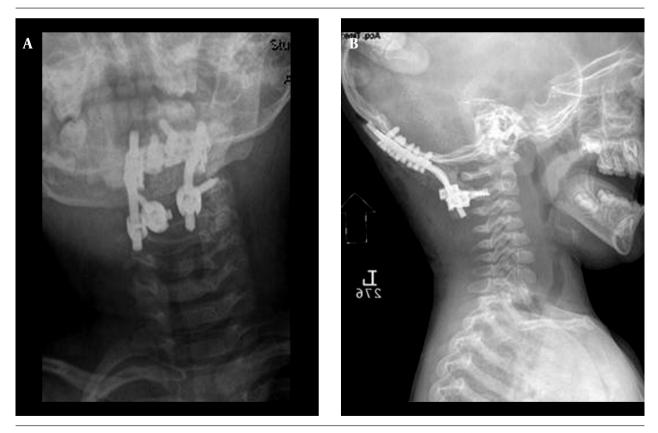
A, Anteroposterior and B, Lateral Radiographs Showing an Occipitocervical Fusion in a Two-Year-Old Girl Involved in a Motor Vehicle Accident With Occipitoatlantal Instability
